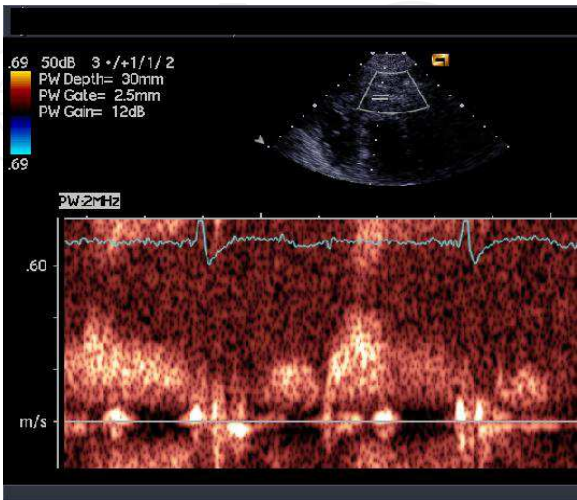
Pulsed-wave Doppler of LAD blood velocity with prominent systolic flow
